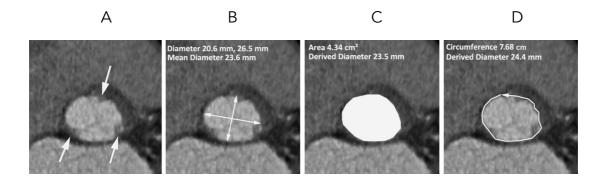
Measurement of the aortic annulus diameter using CT scan. A. The optimal plane includes the three lowest insertion points of the coronary cusps (arrows). B. The short and long annulus diameters are measured and the mean diameter in calculated. C. The annulus area is measured and the mean diameter is derived assuming circularity of the annulus. D. The perimeter of the annulus is measured and the mean diameter is derived assuming circularity of the assuming circularity of the annulus.
